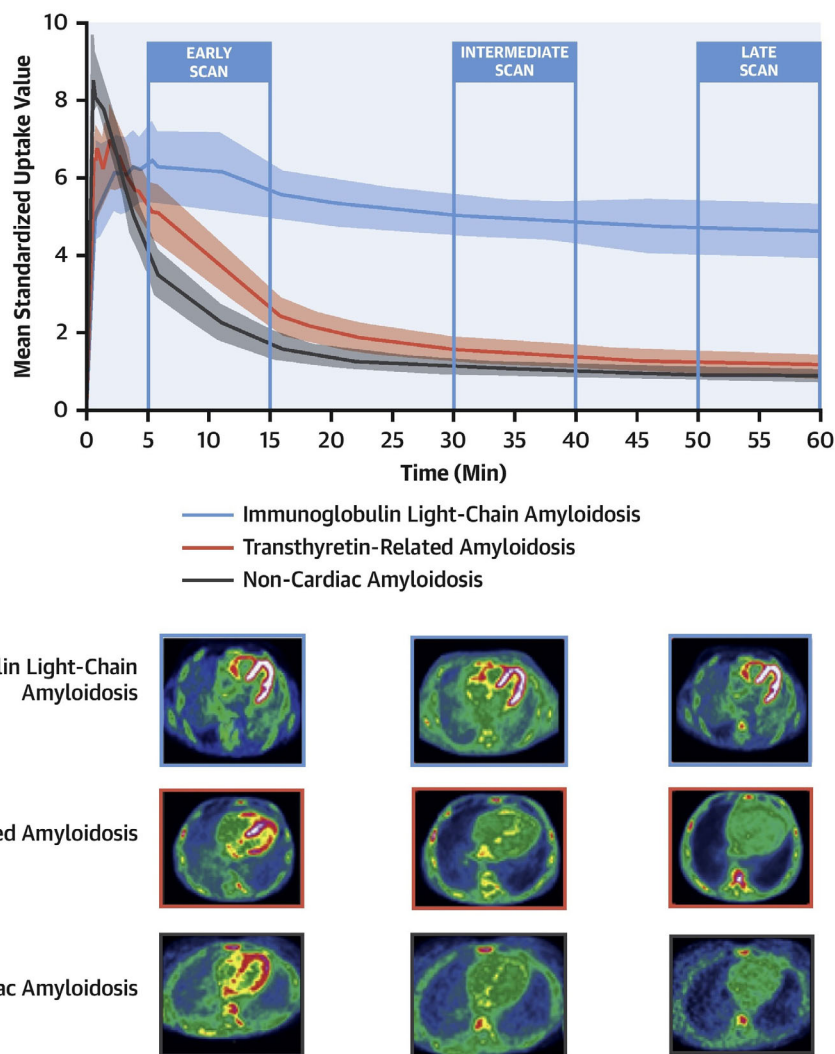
Cardiac ^{18}F -florbetaben uptake in patients with and without cardiac amyloidosis. *Upper panel:* ^{18}F -florbetaben cardiac positron emission tomography myocardial time–activity curves in patients with immunoglobulin light-chain amyloidosis, transthyretin-related amyloidosis, and non-cardiac amyloidosis. The 95% confidence interval is represented as a shaded area for each curve. *Lower panel:* early (5–15 min), intermediate (30–40 min), and late (50–60 min) ^{18}F -florbetaben cardiac positron emission tomography scans in patients with amyloid light-chain and transthyretin-related cardiac amyloidosis and in those with non-cardiac amyloidosis. SUV, standardized uptake value. Reprinted with permission from Genovesi et al.⁷²
